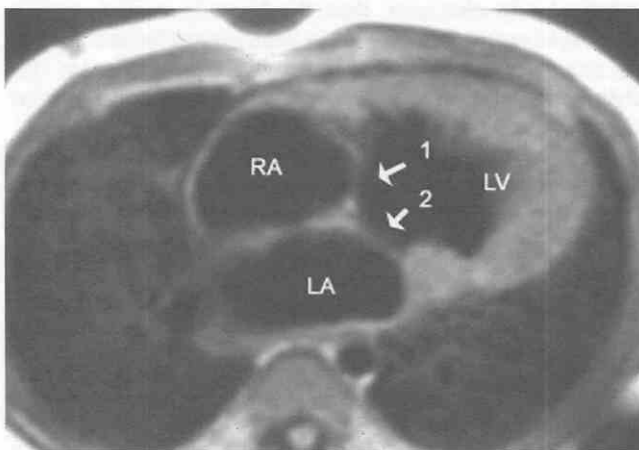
MR image obtained from a 2-year-old boy with a double-inlet left ventricle (see Fig. 33-52). Blood drains from the right atrium (RA) through the anterior atrioventricular valve (*arrow 1*) and from the left atrium (LA) through the posterior atrioventricular valve (*arrow 2*) into a dominant left ventricle (LV).
